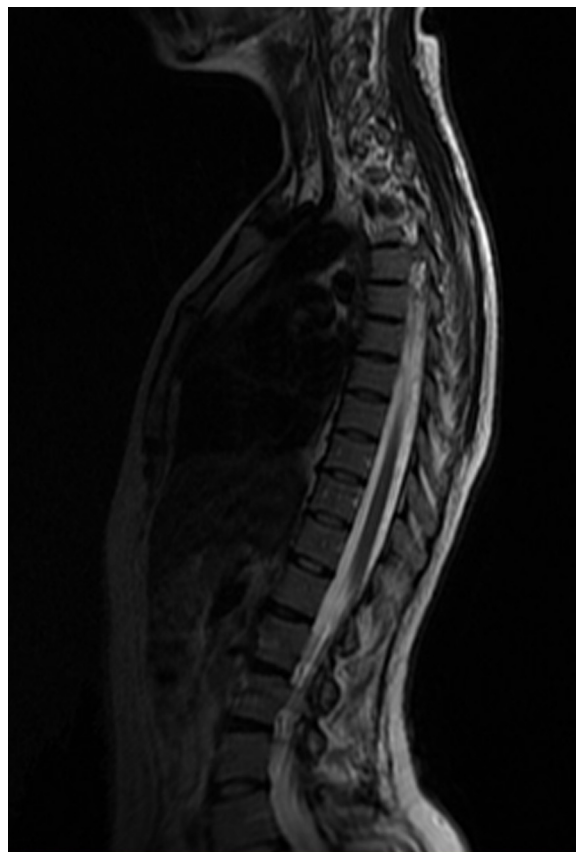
MRI of the spine shows an exaggerated lumbar lordosis.
